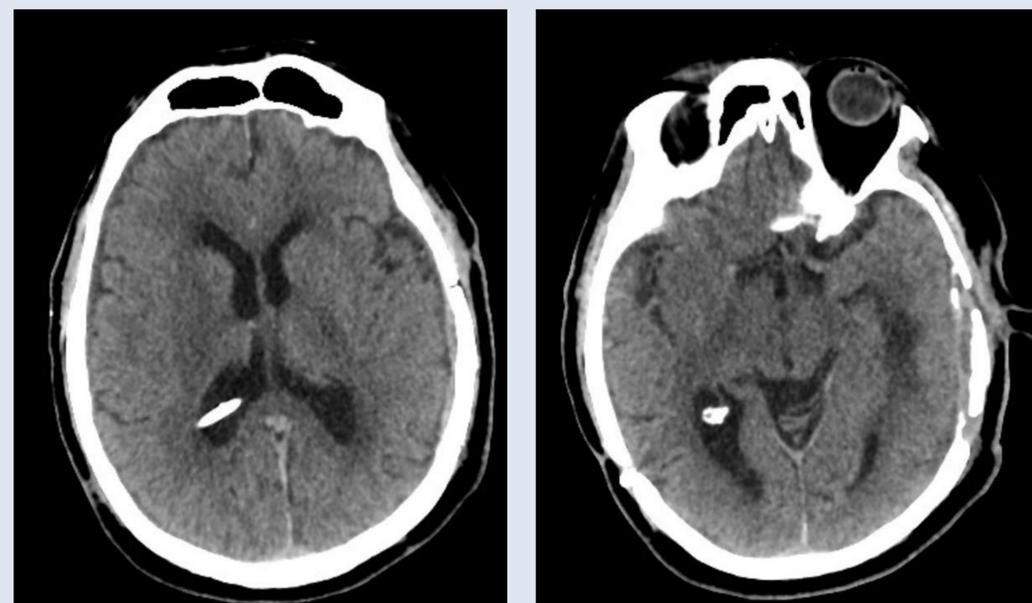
CT-scan 2 months after temporal skull base plasty with a pericranial flap showing a complete resolution of the pneumocephalus.
